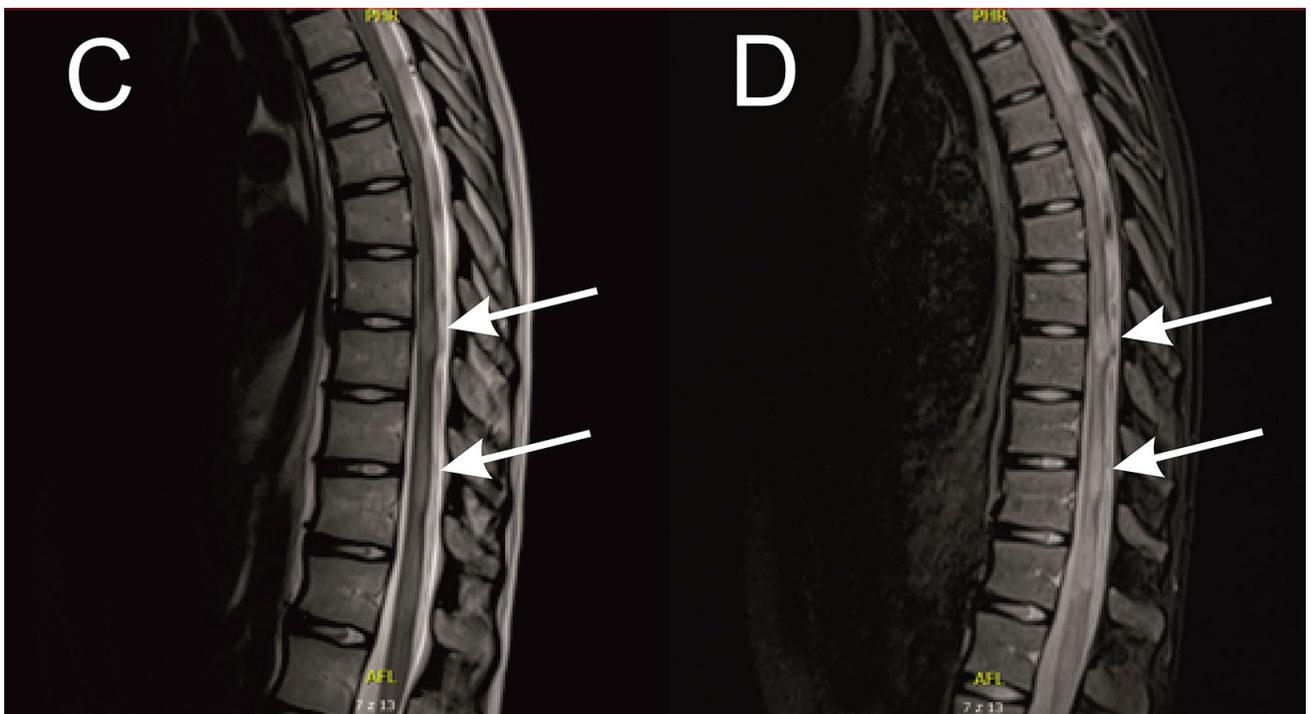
Thoracic spine MRI
